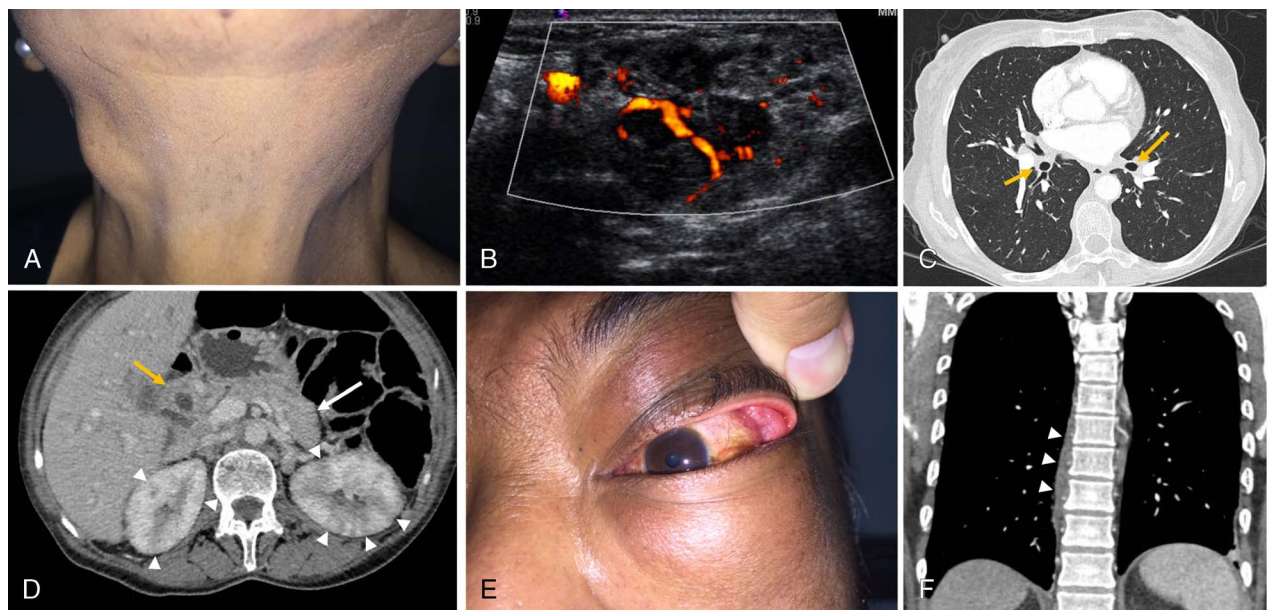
A 62-year-old woman presented with (A) bilateral submandibular gland enlargement; (B) left submandibular gland ultrasound showing reticular and nodal pattern; (C) axial thoracic CT showed peribronchovascular bundle thickening (yellow arrow) and (D) contrast-enhanced axial CT of the abdomen revealed an enlarged pancreas with loss of lobulations (white arrow), common bile duct dilation with concentric wall thickening with smooth lumen surface (yellow arrow), and multiple wedge-shaped, low-attenuation cortical lesions in both kidneys (arrowheads); she had hypocomplementemia, serum IgG4 levels were 7020 mg/dL, and pancreas and common bile duct biopsy corroborated IgG4-RD diagnosis. E, Left dacryoadenitis in a 42-year-old man. F, Coronal CT image showing a left paravertebral mass in a 60-year-old man. Color online-figure is available at <http://www.jclinrheum.com>.
